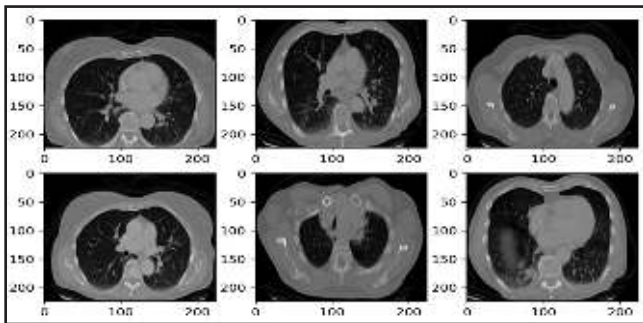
The sample CT images for lung cancer dataset.
